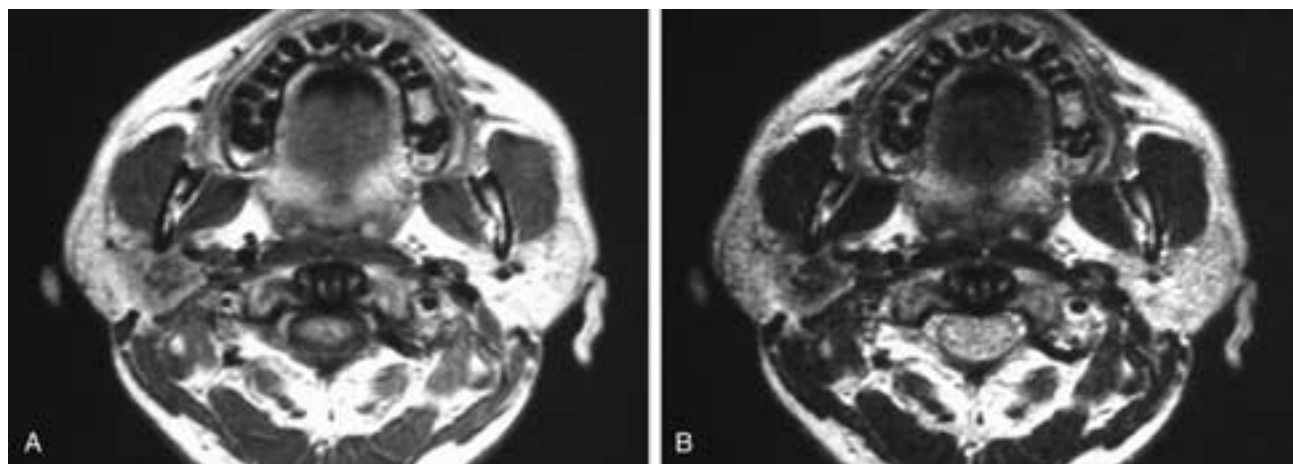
Axial proton density (A) and T2-weighted (B) MR images show a poorly defined mass in the deep portion of the right parotid gland. The mass had low signal intensity on all imaging sequences. This patient had an adenocarcinoma.
